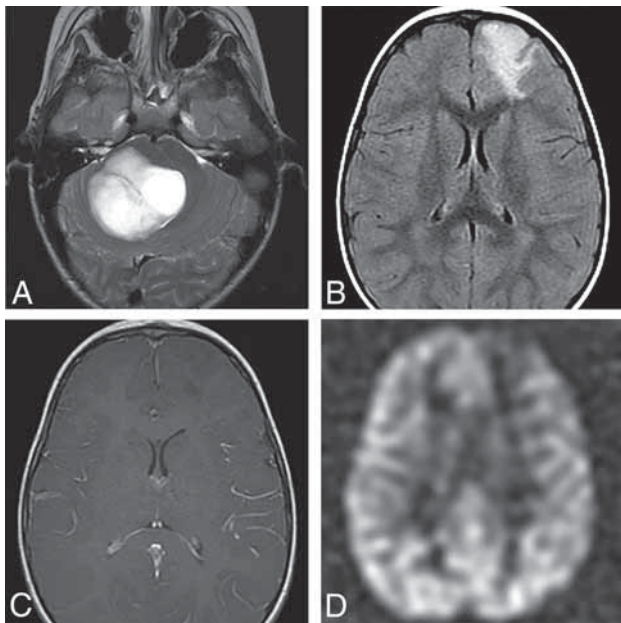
Pediatric-type diffuse low-grade glioma. Axial T2 (A) MR image in a 7-year-old boy with a diffuse astrocytoma, *MYB*-altered, shows a hyperintense mass in the pons with no significant surrounding edema. There was no enhancement and no diffusion restriction of the mass (not shown). Axial FLAIR (B), postcontrast T1 (C), and arterial spin-labeling (ASL) (D) in a 1-year-old child with an angiocentric glioma show a FLAIR hyperintense mass involving the cortex and subcortical white matter of the left frontal lobe. There is no enhancement (C) and decreased perfusion (D) on ASL imaging.
